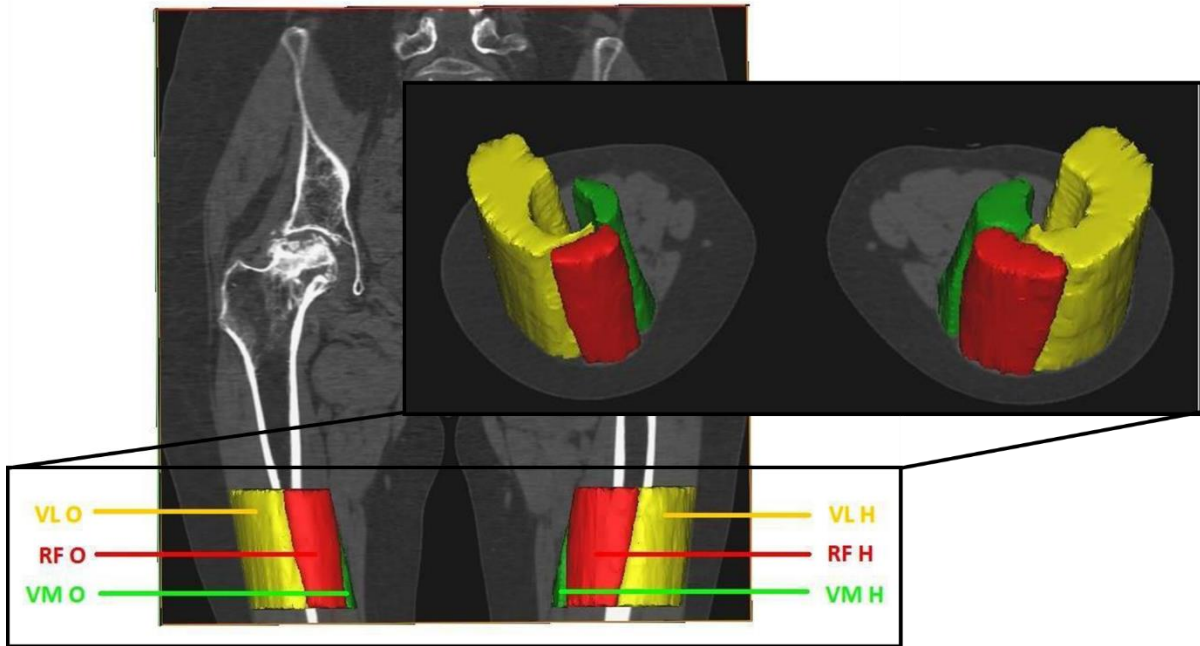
Representative 3D soft tissue segmentation of the *Rectus femoris*, *Vastus lateralis*, and the *Vastus medialis*. Images were obtained from a 64-slice spiral CT scanner and assembled using MIMCS software. [337]
